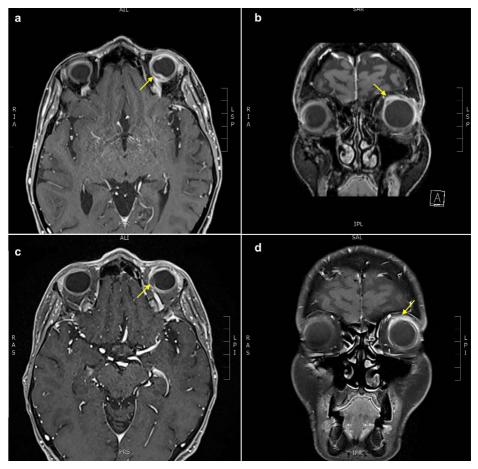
MRI brain with T1-weighted imaging. (*a*, *b*) At presentation, thickening and enhancement of the left sclera with superomedial contour deformity consistent with scleritis and subchoroidal effusion. There was enhancement of the orbital optic nerve. (*c*, *d*) Following surgical excision with local and systemic antifungal treatment, there were improved but persistent inflammatory changes, as demonstrated by the hyperintense signal around the left globe and the residual superomedial subchoroidal collection.
